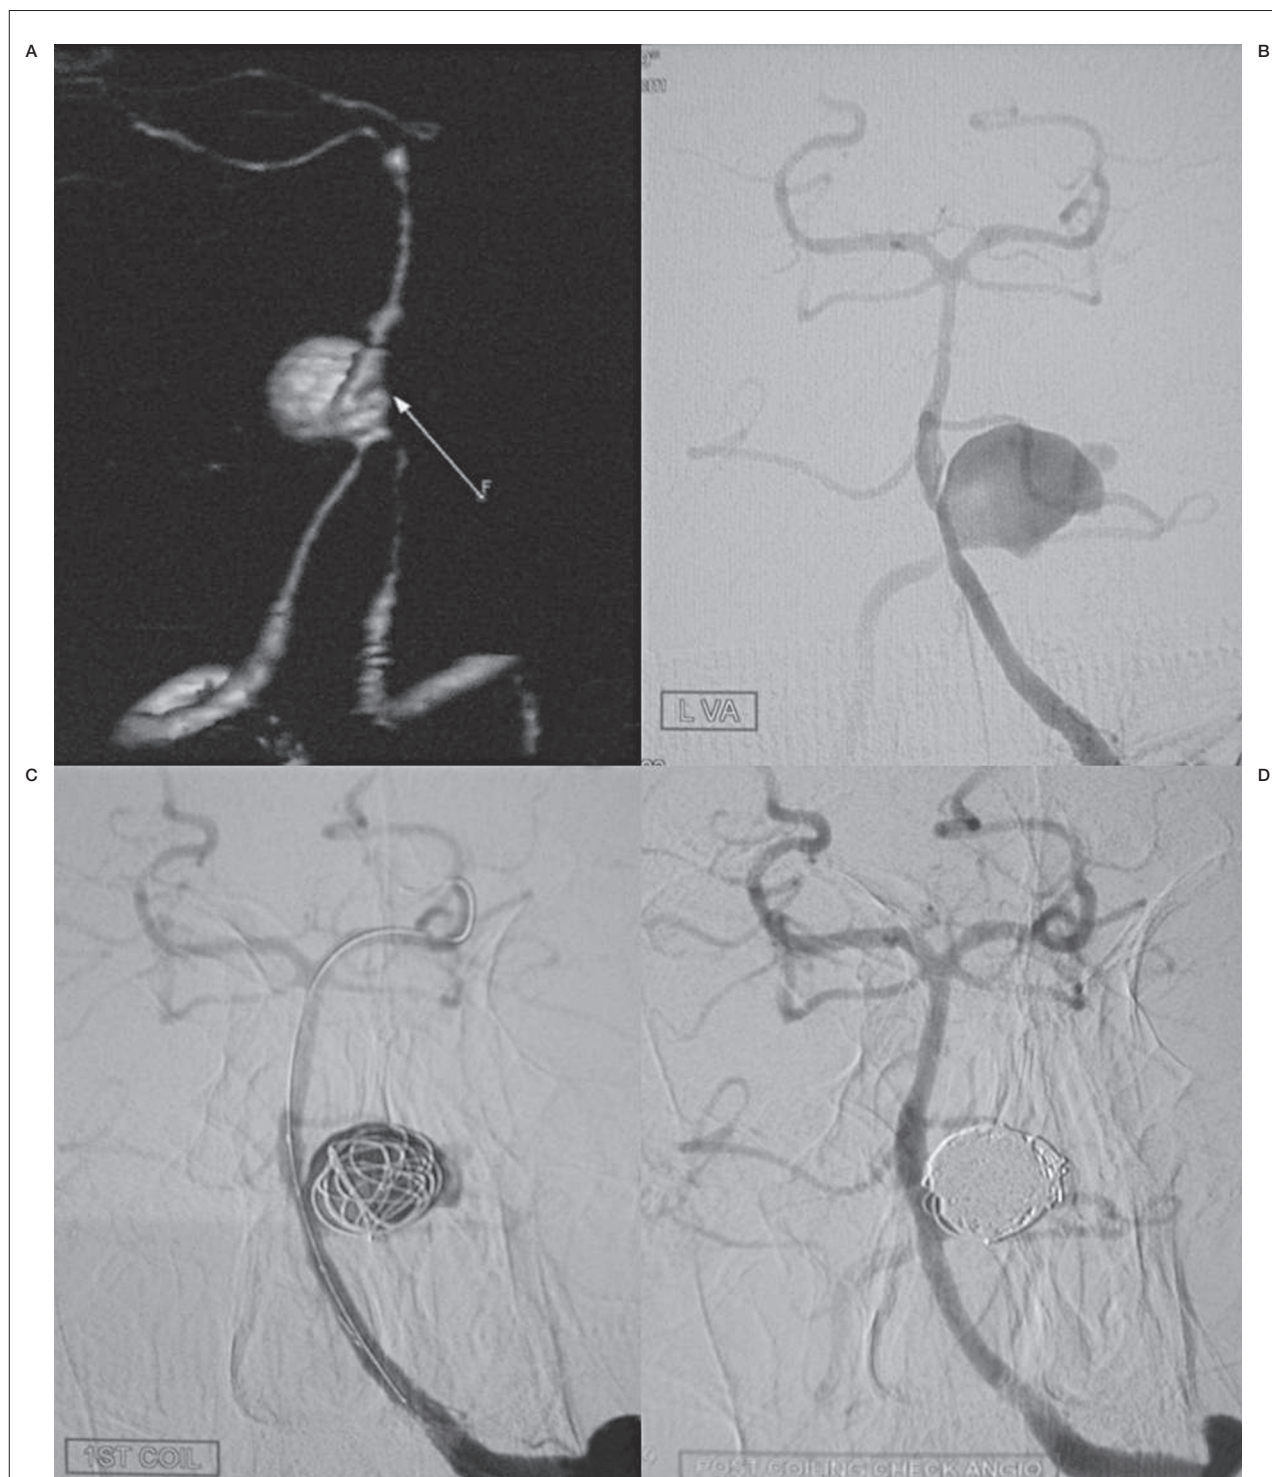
CT angiogram (A) and angiogram (B) showing a large aneurysm arising from the proximal bifurcation of the fenestration (arrow in A). Angiogram during (C) and after (D) coil embolization showing complete obliteration of the aneurysm.
